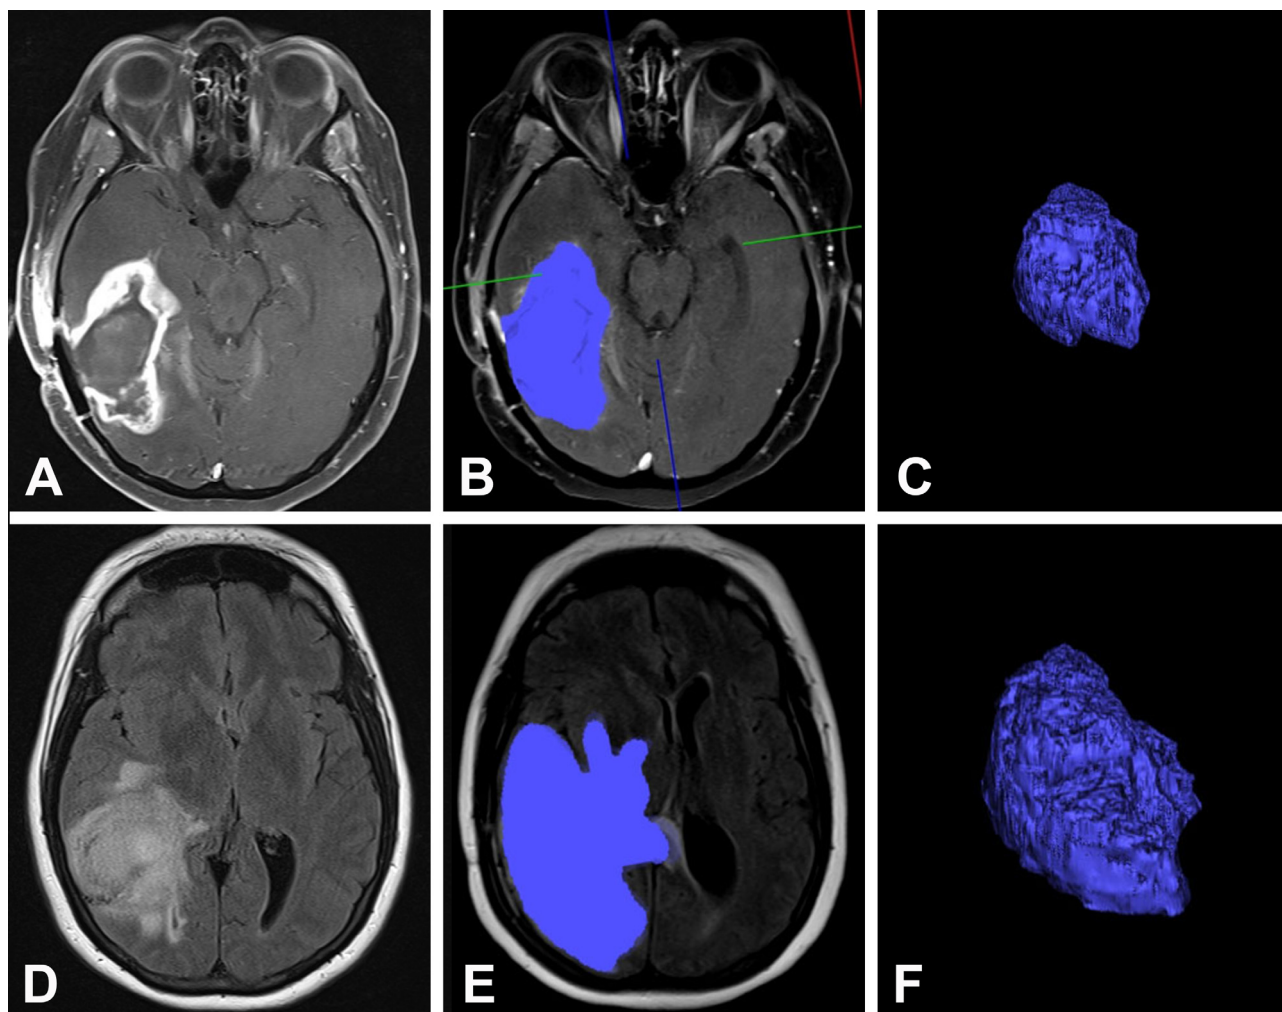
Representative case using the Vitrea Core software demonstrating volume measurement of a right posterior temporoparietal glioblastoma. A) Axial MRI with contrast. B) 2D measurement of area of enhancement. C) 3D rendering of volume of enhancement. D) Axial MRI FLAIR sequence. E) 2D measurement of area of FLAIR signal change. F) 3D rendering of volume of FLAIR signal change.
